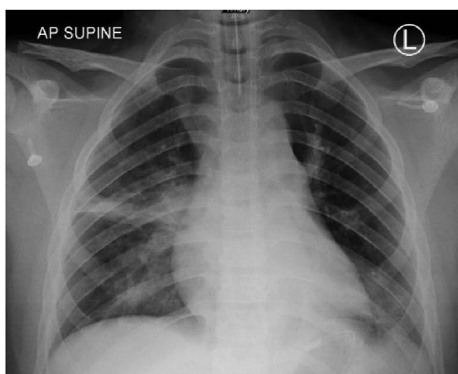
Chest radiograph before bronchoscopy showed an intubated patient with hyperlucency of the left hemithorax with segmental collapse of the left lower lobe. No radioopaque lesion noted within the bronchus. There were consolidative changes in the perihilar region of the right middle and lower zones.
